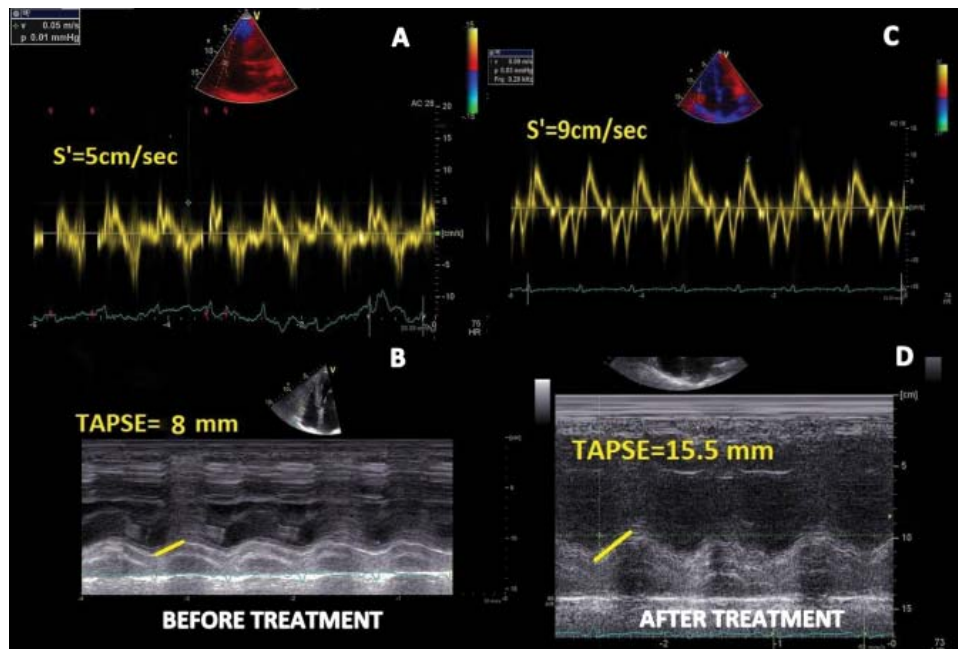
Transthoracic echocardiographic images for right ventricle before and after chemotherapy and stem cell transplantation. A and B (before treatment): altered longitudinal systolic function (TAPSE = 8 mm, S' = 5 cm/sec) at initial diagnosis; C and D (after treatment): improvement in longitudinal systolic (TAPSE = 15.5 mm, S' = 9 cm/sec) at 6 months follow up. TAPSE: tricuspid annular plane systolic excursion; s' = peak systolic velocity.
